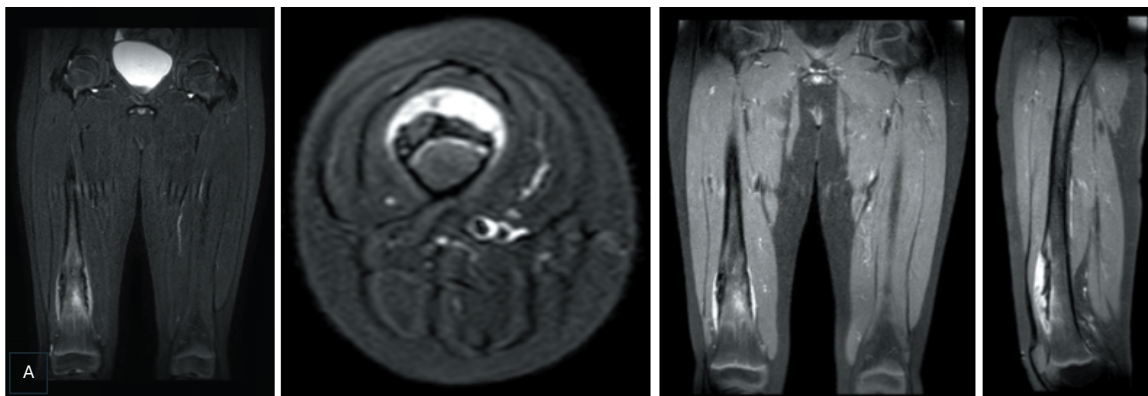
MRI of the right femur revealed an osteolytic lesion (arrow) with high signal intensity on STIR sequences (Figures A, B) and contrast enhancement post-gadolinium administration (Figures C, D), located subperiosteally on the cortical surface of the distal third of the femur. This was accompanied by subjacent cortical thickening and an irregular periosteal reaction. Bone marrow edema was also observed, showing high signal intensity on STIR (Figures A, B) and contrast enhancement (asterisk) (Figures C, D). No evidence of invasion into surrounding soft tissues was noted.
